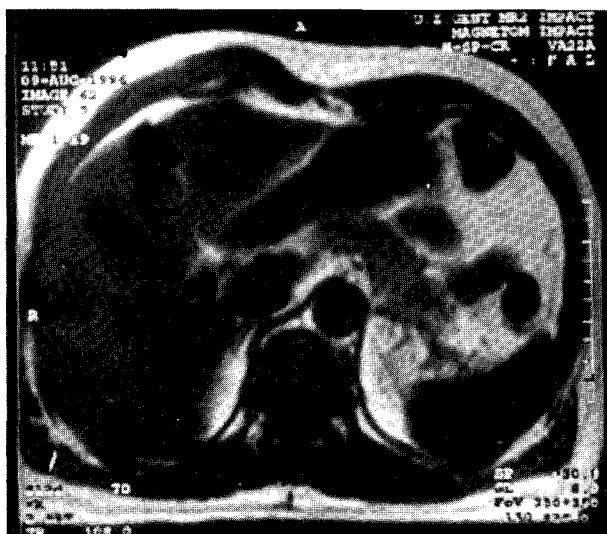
Fat suppressed MRI T1 image shows focal hypointense lesions in segment VII of the liver.
